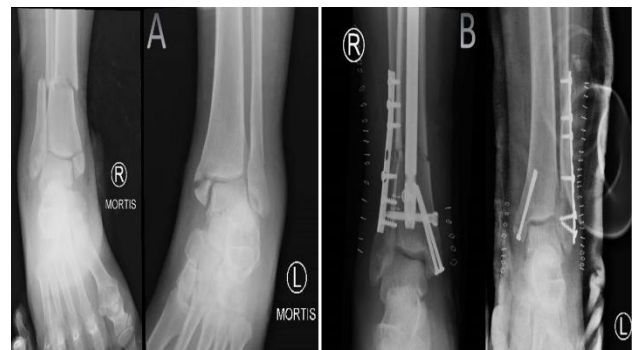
Case 3 Anteroposterior pre-operative; A) and Post-operative, B) X-rays showing a left sided SER IV, and a right sided PER IV with an associated distal tibial metaphyseal fracture.
